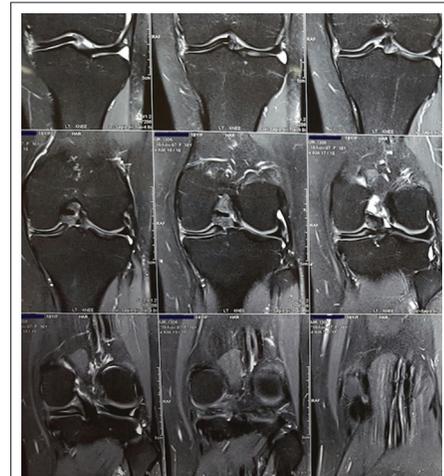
Magnetic resonance imaging showing discoid medial meniscus in coronal cuts.
